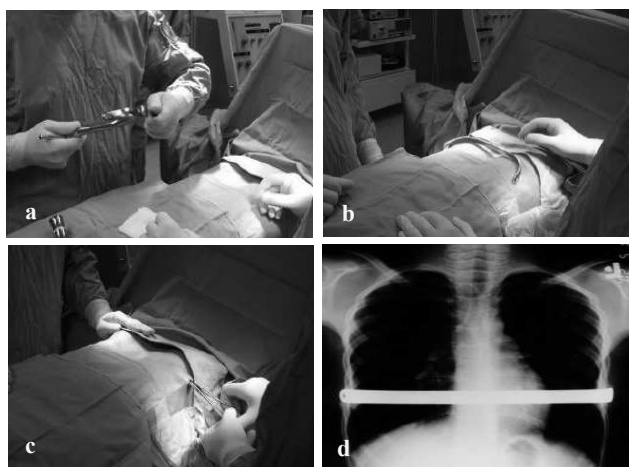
Implantation technique of fixation plate - Nuss method: a,b – modelling of the plate, c - insertion of bent plate, d – Xray of the chest after implantation [3,5]
